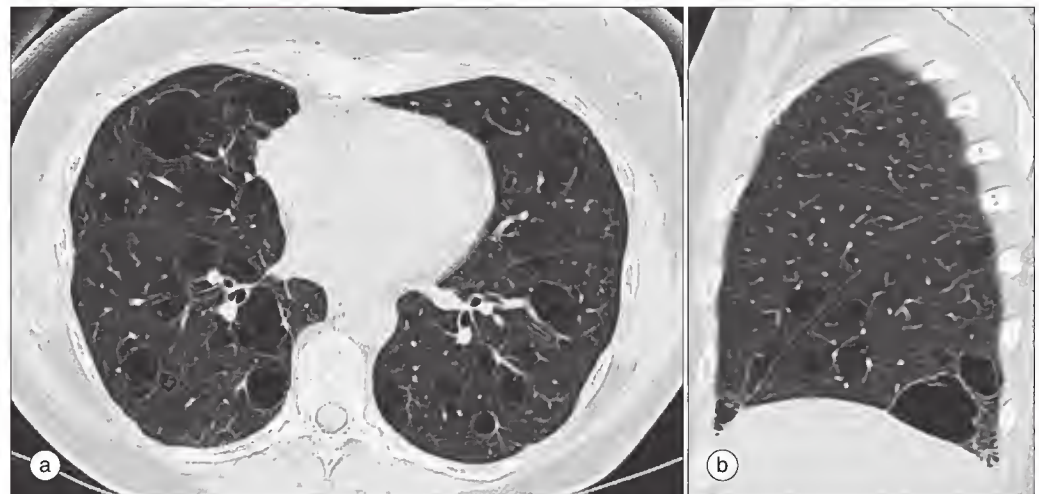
(a and b) Cystic lung lesions. These computed tomography images show multiple thin-walled pulmonary cysts in a woman with Sjögren syndrome.
